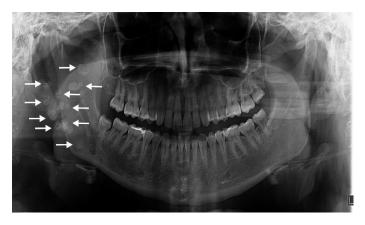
Panoramic radiograph exposing multiple randomly distributed round-to-oval radiopaque structures with a variable size, overlying the right mandibular ramus (white arrows).
